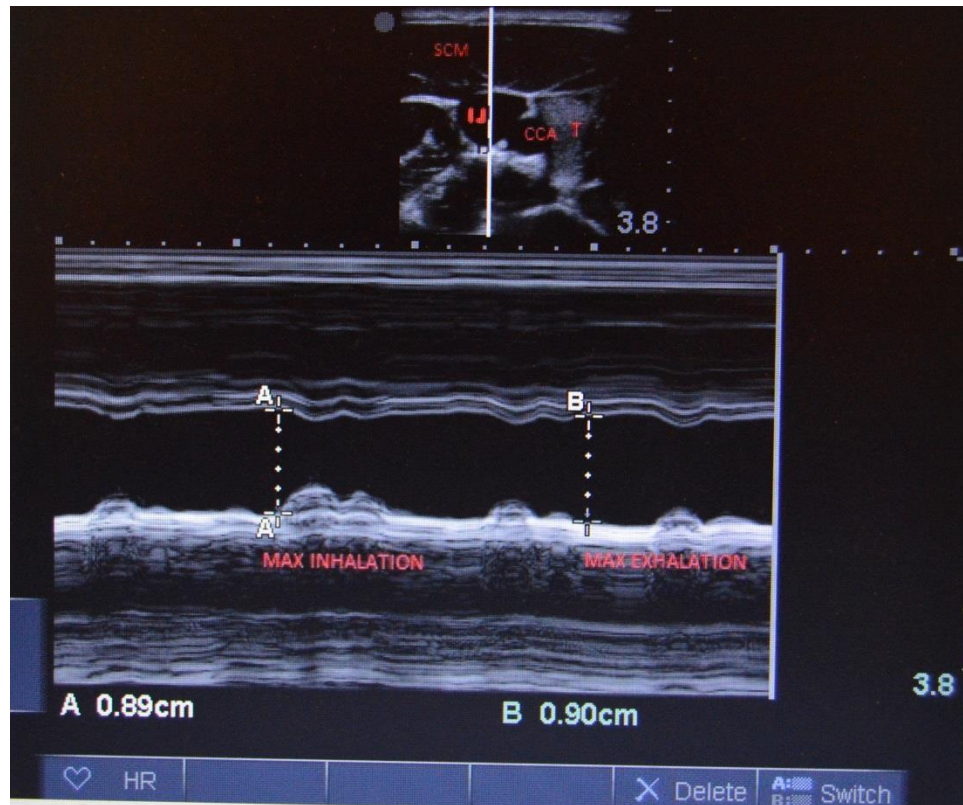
Ultrasound measurements of right internal jugular vein in M Mode (in cross section and corresponding M-mode tracing).
